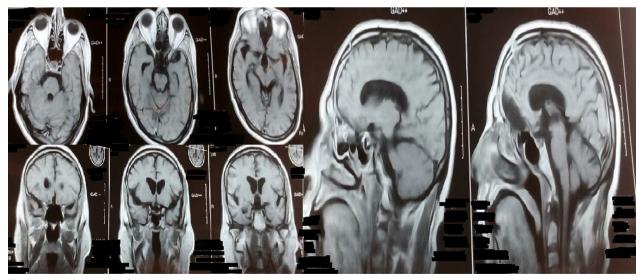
Post-operative MRI of patient 3
